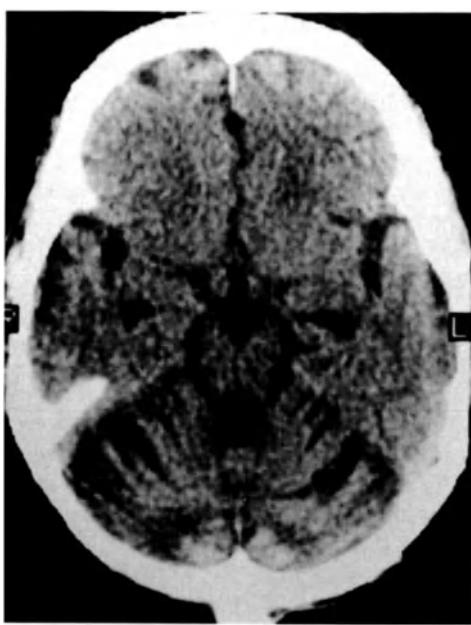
CT showing focal atrophy of brainstem and cerebellum.
